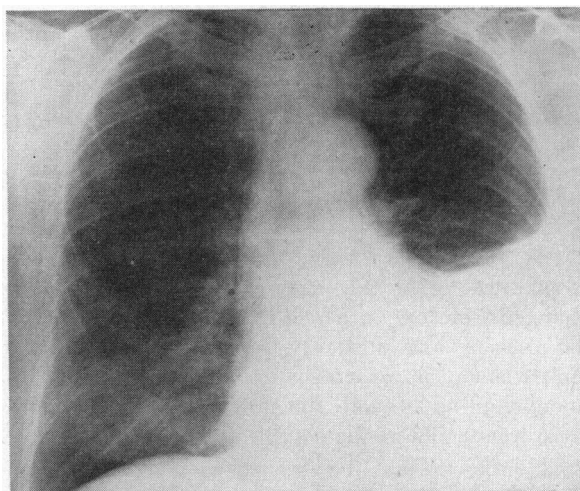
(Case 1).—X-ray film showing left pleural effusion before thoracentesis.
